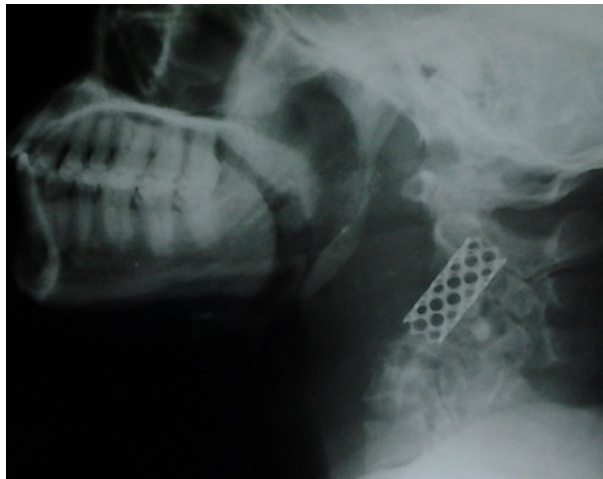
Plain cervical spine X-ray following the 2nd stage.
